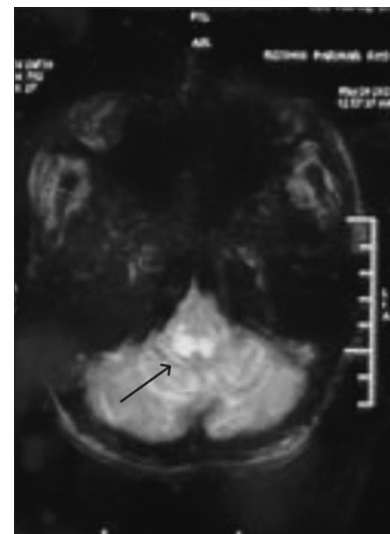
Magnetic resonance imaging findings of the brain
